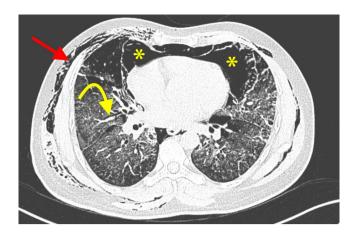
Axial computed tomography (CT) chest image of a 34-year-old male patient with COVID-19 demonstrating extensive ground-glass opacities of the lung parenchyma, Macklin effect (curved yellow arrow), pneumomediastinum (asterisks), and subcutaneous emphysema (straight red arrow).
